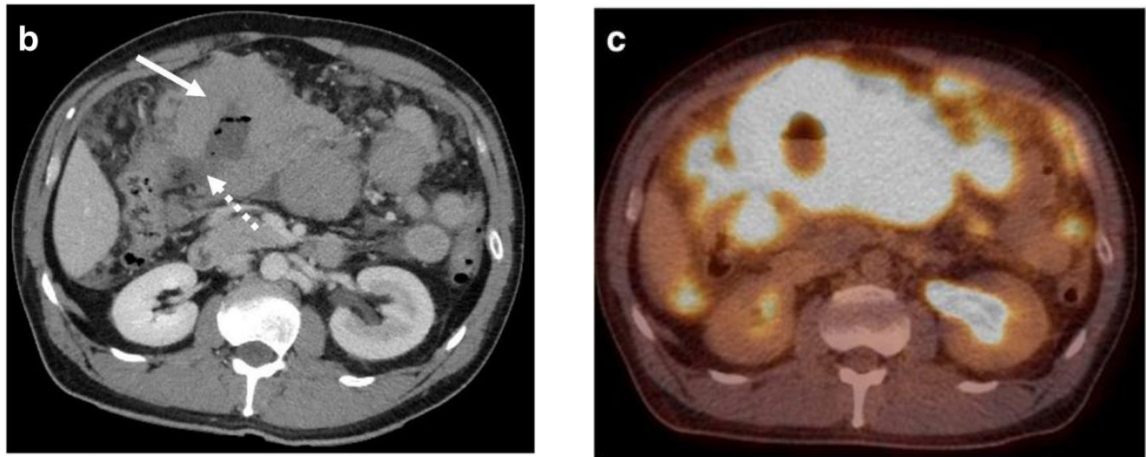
Picture b showing a bowel perforation on an Axial CT scan (dashed arrow) and the associated solid mass (solid arrow). Picture c is a follow-up of the same patient using a Fused Axial PET-CT demonstrating extensive abdominal involvement and hypermetabolic activity associated with BL. (16)
